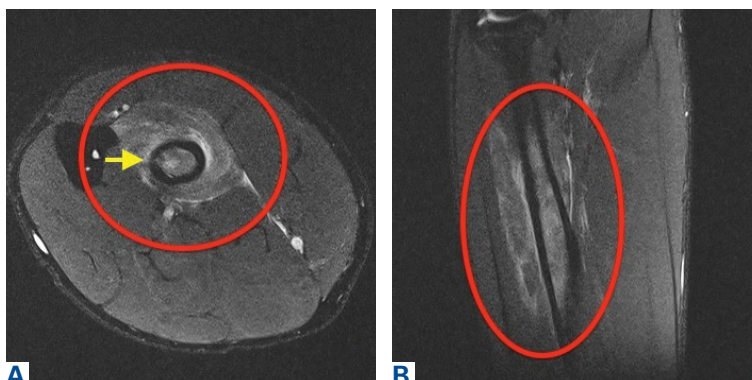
(A) Axial and (B) coronal T2-weighted magnetic resonance imaging of the right radius shows periosteal, cortical, and marrow edema. Reactive myositis surrounds the fracture (yellow arrow).
